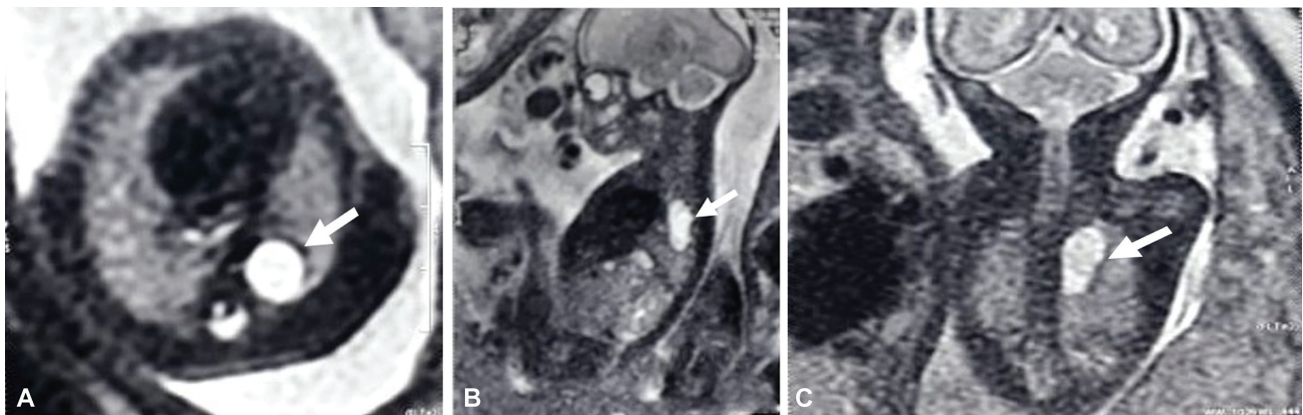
Fetal magnetic resonance imaging (MRI). (A) A small anechoic cyst (white arrow) in the posterior mediastinum in the axial section of the fetal thorax measuring $22 \times 13 \times 12$ mm. (B) Sagittal section of the fetal thorax showing avascular cyst. (C) Coronal section of the fetal thorax shows the proximity of the cyst to the hemivertebral segment.
